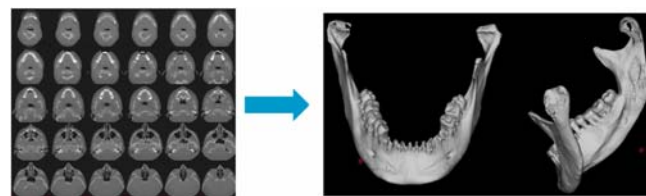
Conversion of two dimensional computed tomography images into a three dimensional solid body model.
